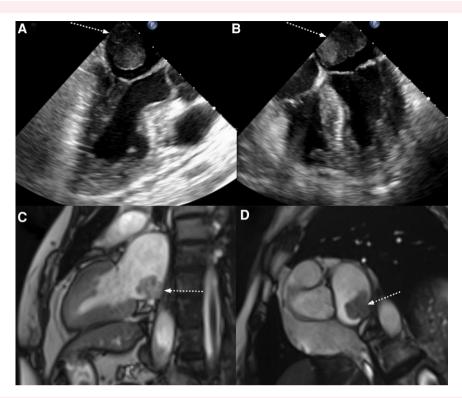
Transoesophageal echocardiography: (A) three-chamber view and (B) four-chamber view—voluminous mass (arrow) in the left atrium. Cardiac magnetic resonance imaging: (C) vertical long-axis and (D) short-axis view—mass (arrow) arising from the inferior wall of the left atrium.
